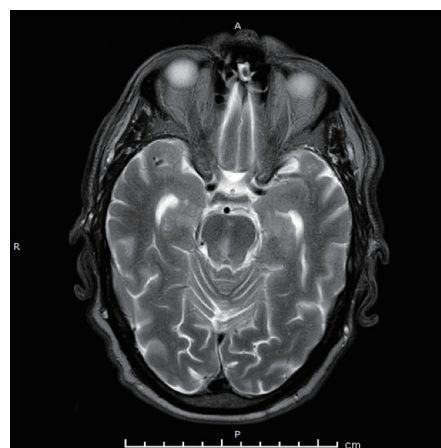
T2 weighted image from the same patient demonstrating the acute stroke in the right caudal midbrain. Device: 3-Tesla MRI. Slice thickness: 4 mm.
